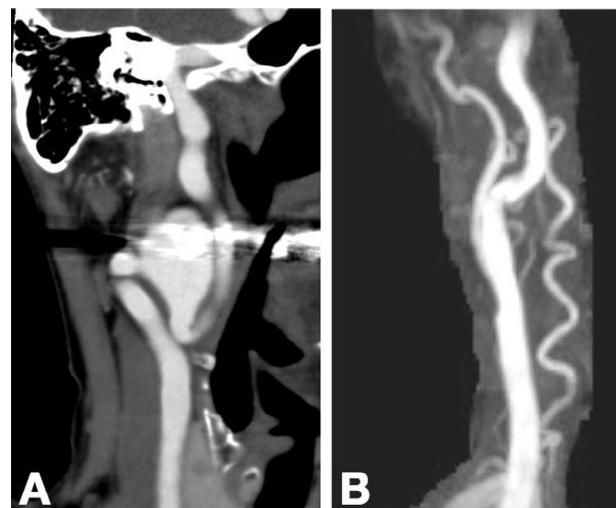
Three-dimensional computed tomography angiography of the right extracranial carotid artery before (A) and after (B) surgery in case 1.
